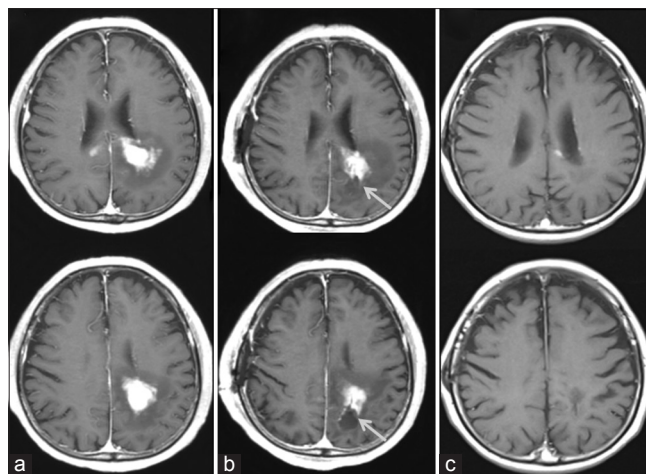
A representative malignant lymphoma case (patient 29) of navigation-guided rigid endoscopic biopsy using the single port technique for the deep white matter lesion of the left parietal lobe. ((a) axial view of T1-weighted images (WI) after gadolinium administration before the biopsy; (b) T1-weighted images-gadolinium 1-day after the biopsy; (c) T1-weighted images-gadolinium after chemotherapy)
